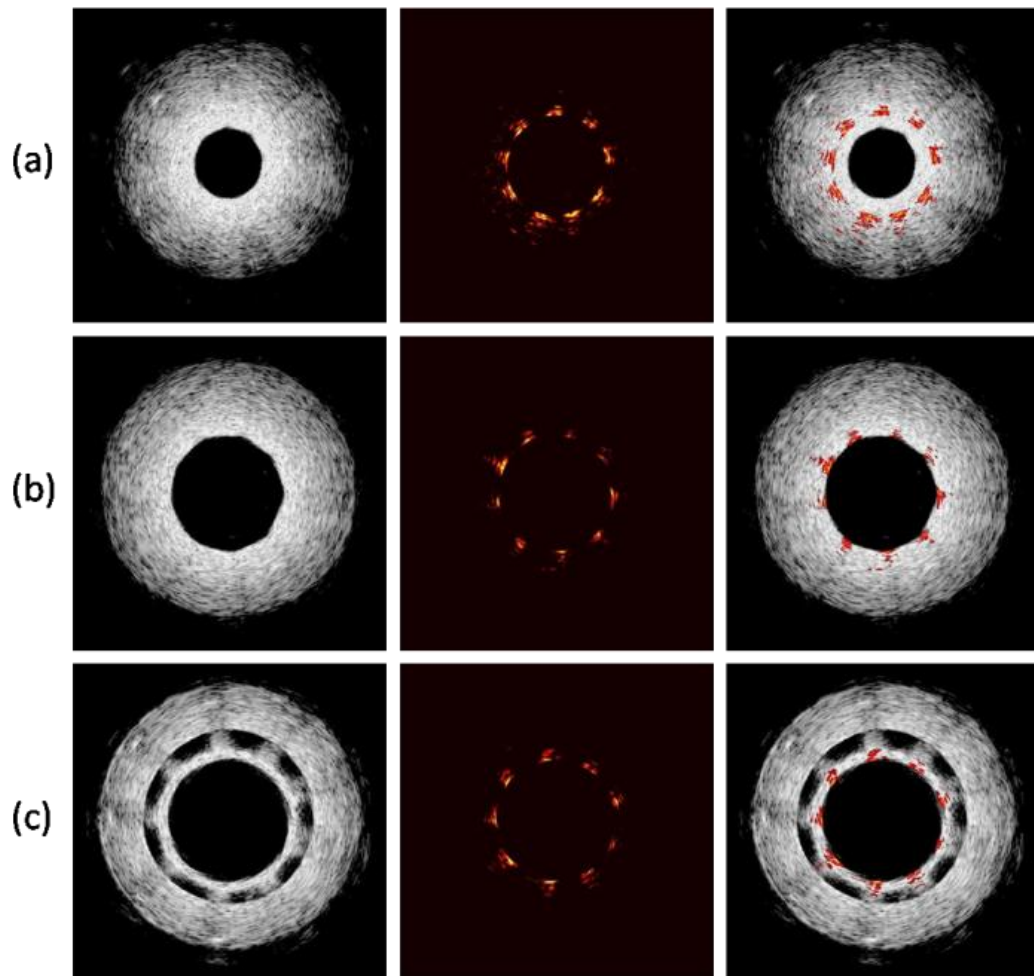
Intravascular ultrasound and photoacoustic and combined IVUS/IVPA images from the three different regions in the stented vessel. (a) Stent embedded within the vessel. (b) Stent adjacent to lumen wall. (c) Stent detached from lumen wall.
